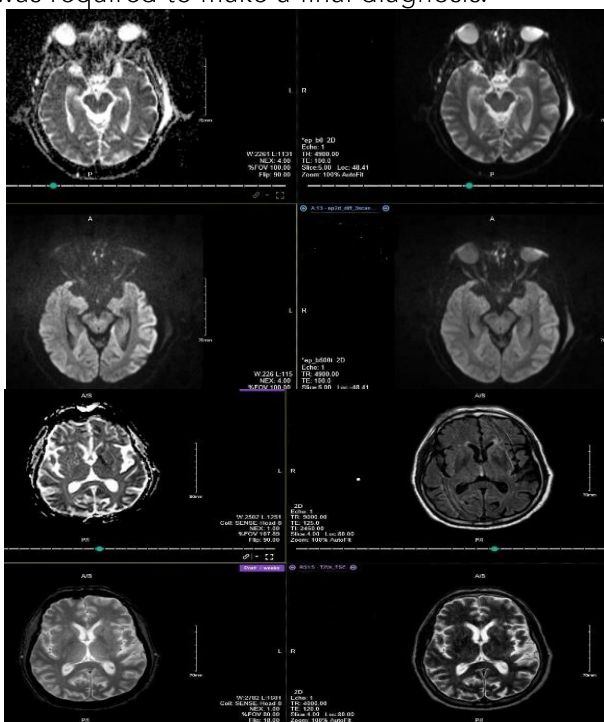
Axial DWI MR images demonstrate Post seizure: Subtle asymmetric gyrfiform restricted diffusion involving the left parieto-occipital and temporal region with a subtle FLAIR hyperintense correlate. This could represent postictal change, however, differential possibilities include Creutzfeldt Jacob disease.
